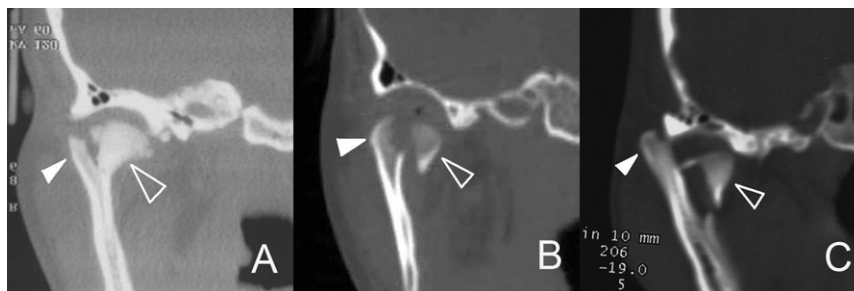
CT images of SFMCs. (A) Type I, a V-shaped gap was formed between the fragment (hollow triangle) and the lateral pole (solid triangle) of the condyle. (B) Type II, the fractured fragment (hollow triangle) was anteromedially displaced, and the lateral pole was still located within the joint fossa. (C) Type III, the lateral pole (solid triangle) of the condyle was superolaterally displaced, and the fractured fragment (hollow triangle) was anteromedially displaced.
